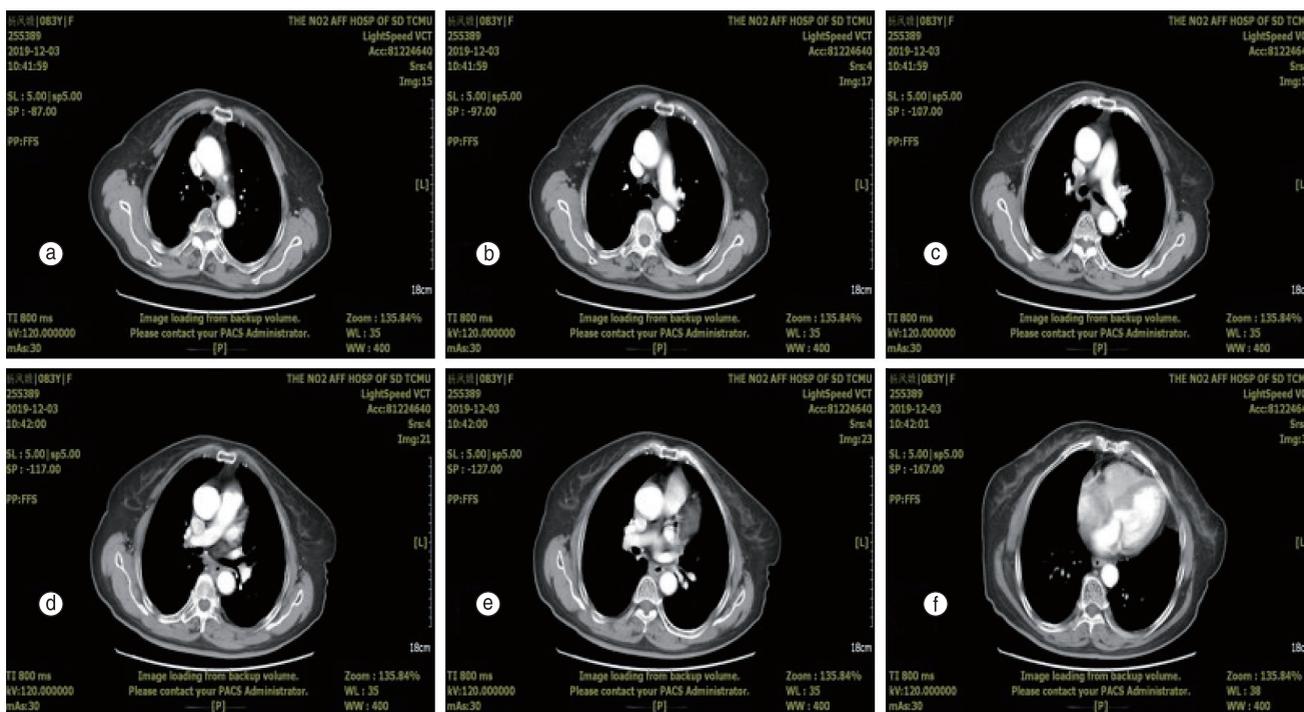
CT after 2 cycles of treatment on December 3, 2019 shown: After esophageal melanoma chemotherapy, the review was significantly better than before, reaching partial remission. The esophageal occupation decreased significantly compared with the previous one, and the mediastinal lymph nodes decreased significantly
